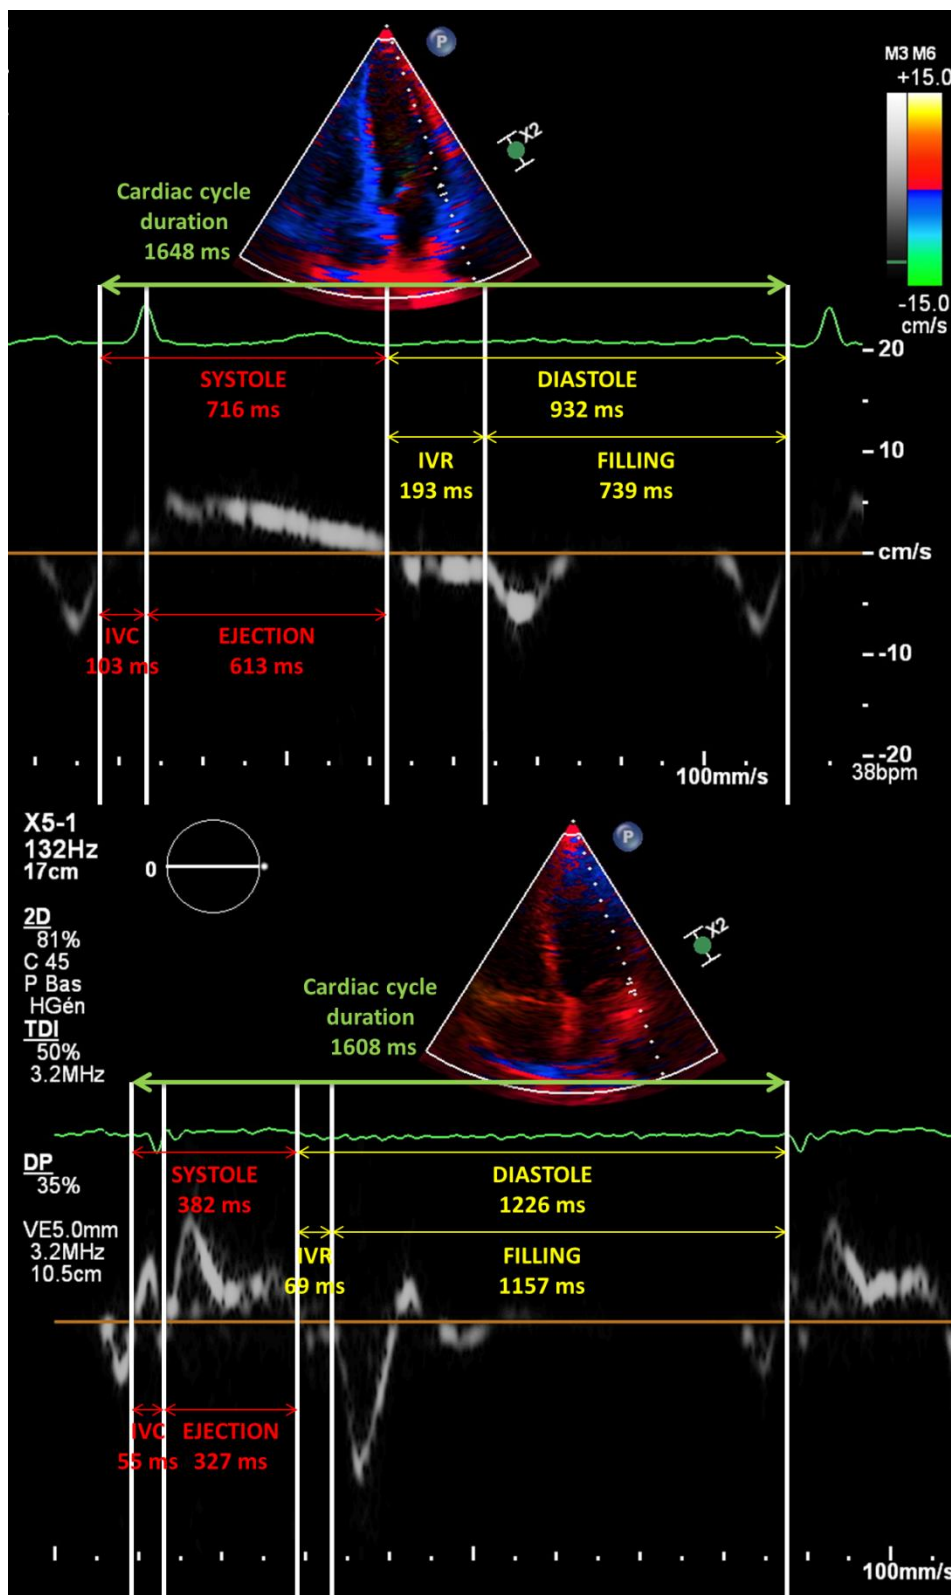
Comparison of tissue Doppler imaging at lateral mitral annulus between our hypothermic patient (at the top) and a normothermic patient (below). IVC: isovolumic contraction time, IVR: isovolumic relaxation time.
